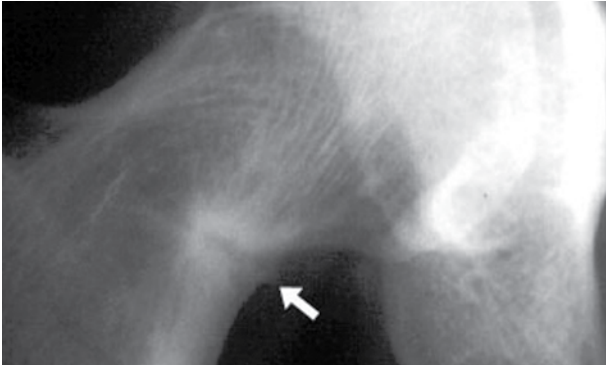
Hip X-ray of the patient demonstrating a pseudofracture in the metaphyses of the femur
